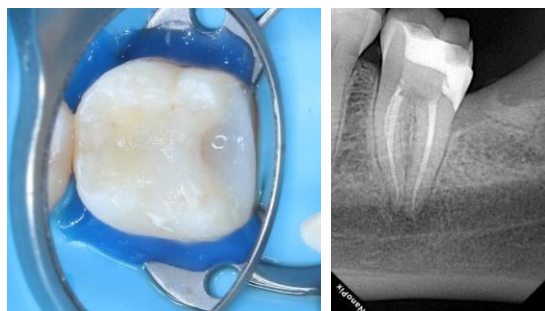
a) DME results in the distal proximal section b) Evaluation of DME results using periapical radiography, showing good edge adaptation and no void.
